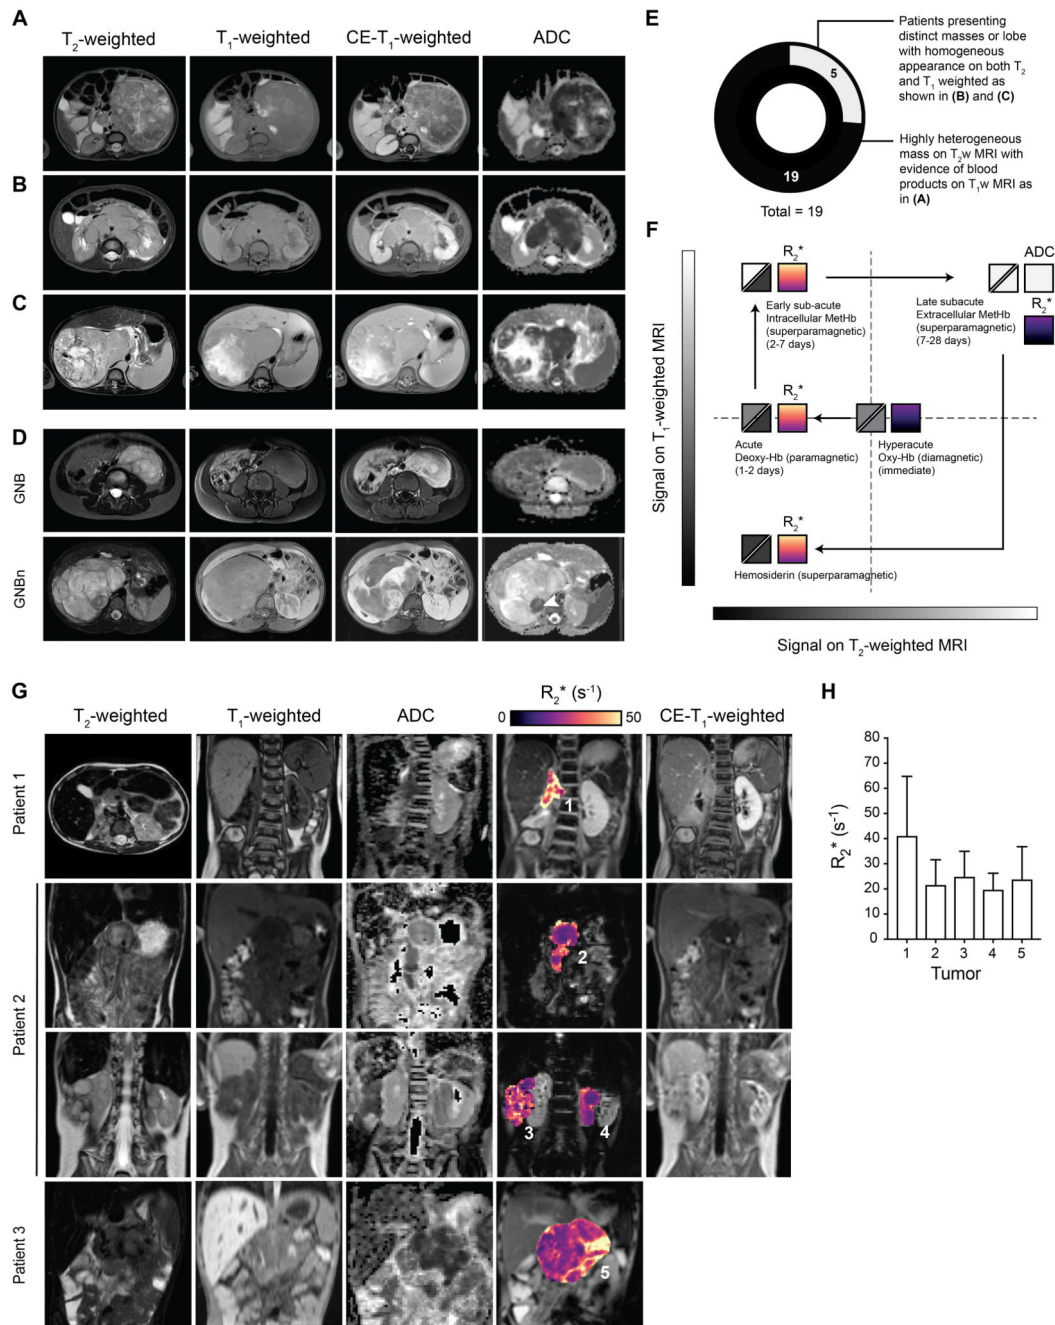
Hemorrhage in *MYCN*-amplified childhood neuroblastoma MRI and initial experience with SW-MRI in the neuroblastoma clinic. (A-C) show abdominal axial fat-suppressed STIR T₂-weighted-MRI images, fat-suppressed SPAIR T₁-weighted MRI images, before and after administration of gadolinium (Gd)-based contrast agent, and diffusion-weighted MRI-derived apparent diffusion coefficient (ADC) maps of children with neuroblastoma (NB) at the time of diagnosis. (A) *MYCN*-amplified high-risk neuroblastoma in a 10-month old boy, (B) a 2-year old boy, (C) a 8-month-old boy, (D) Comparison between a
